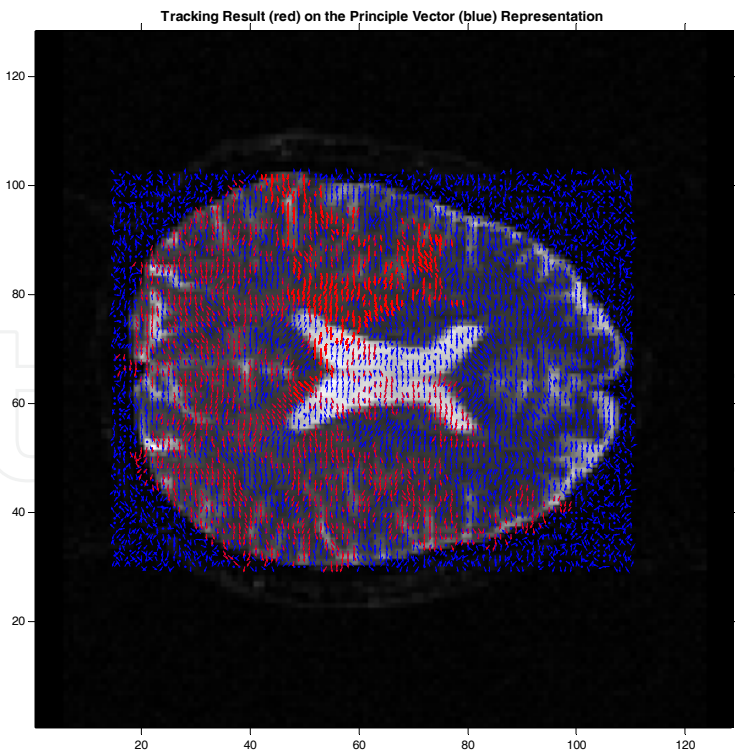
Implementation of the algorithm at the starting point shown in Fig. 5 with a threshold function  $\sigma_1$  allowing a wide range of neighbors as winning nodes results the represented axial slice registered with the anatomic MR image
